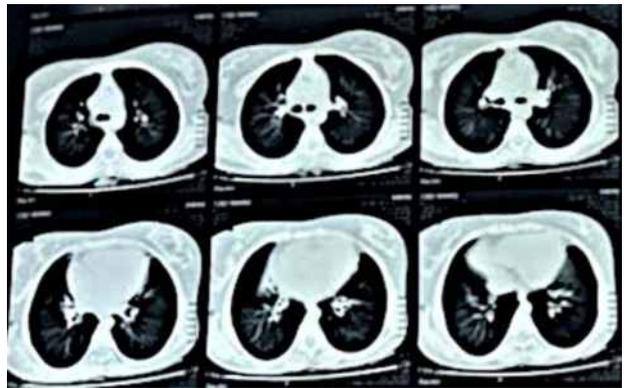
High Resolution CT chest showing bronchiectatic changes in bilateral lungs predominantly in peri-hilar region
